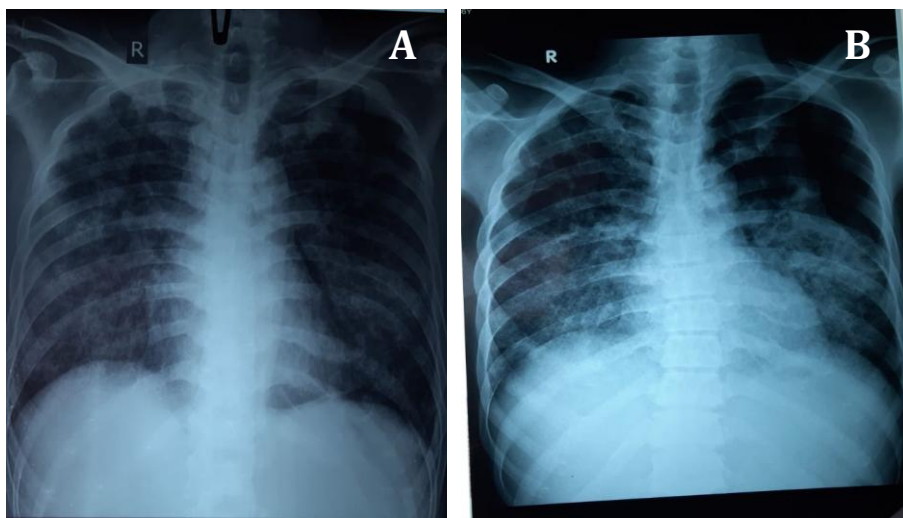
Chest X-ray images A) 06 Jan 2021 and B) 09 Jan 2021, showed pleural TB with secondary infection and left apical pneumothorax but there is an increase in the left apical pneumothorax in fig. B
